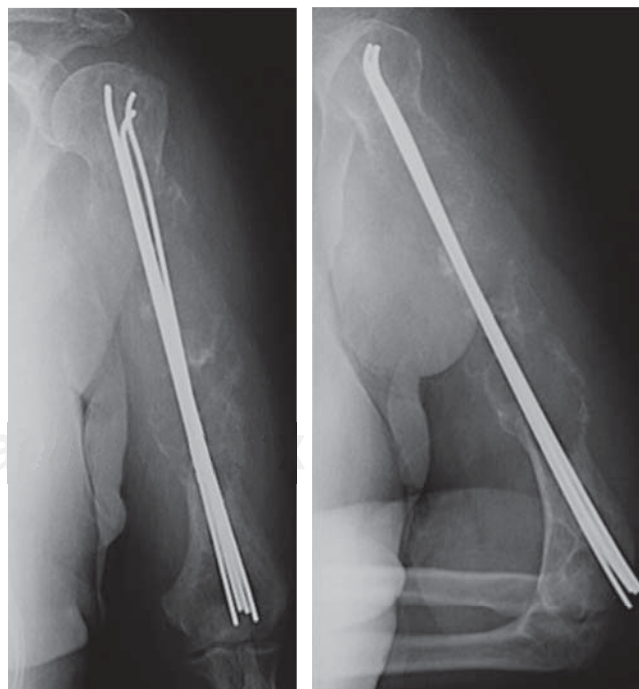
AP radiograph of the humerus which shows intramedullary pinning and gross bone destruction.
